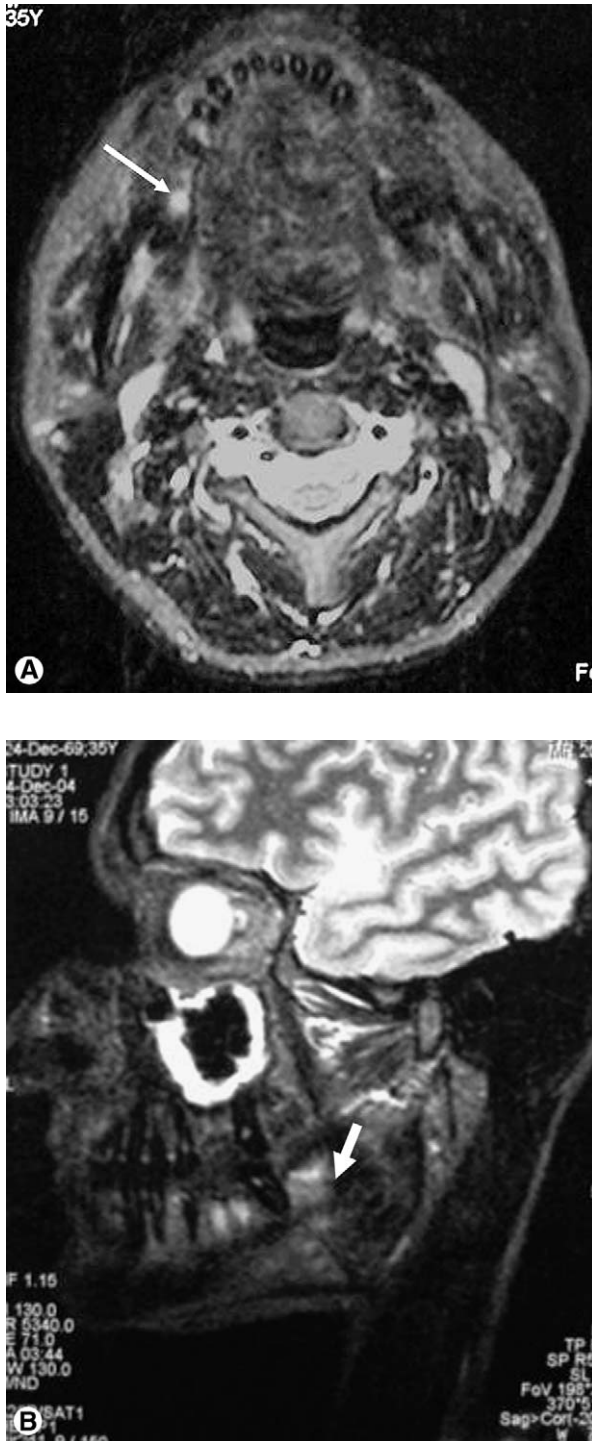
Sagittal (A) and axial (B) fat-suppressed T2-weighted magnetic resonance images of the mandible show bright lesions (arrows), suggesting inflammation and bone marrow edema. Normal bone shows low (dark) signal in this sequence owing to suppression of trabecular bone.
